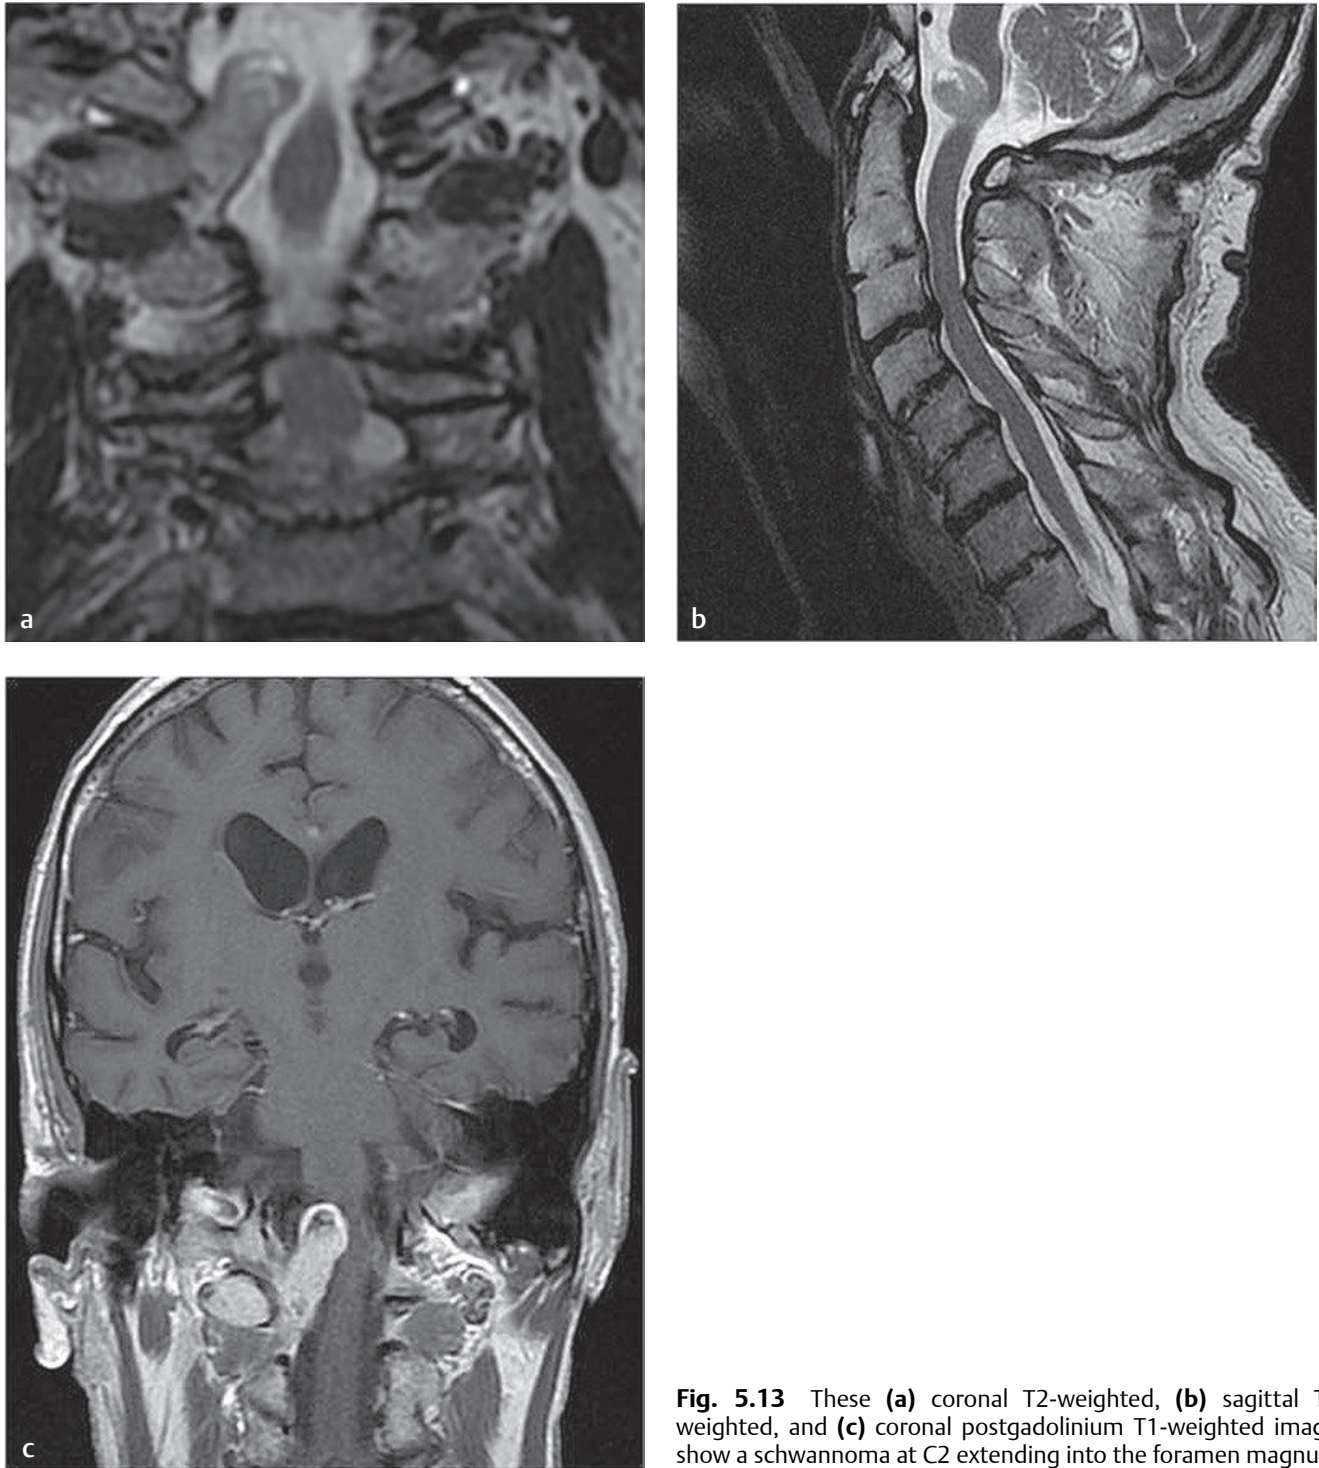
These (a) coronal T2-weighted, (b) sagittal T2-weighted, and (c) coronal postgadolinium T1-weighted images show a schwannoma at C2 extending into the foramen magnum.
